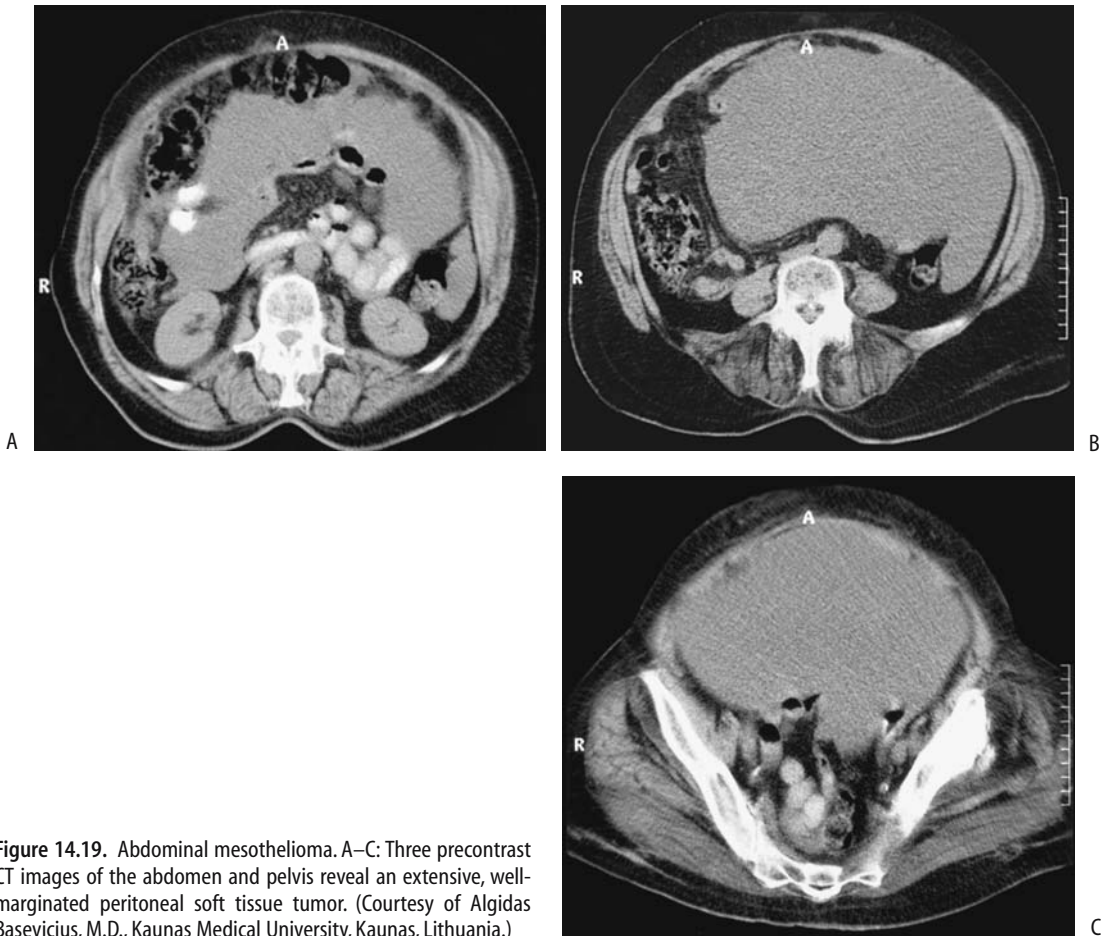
Abdominal mesothelioma. A–C: Three precontrast CT images of the abdomen and pelvis reveal an extensive, well-margined peritoneal soft tissue tumor. (Courtesy of Algidas Basevicius, M.D., Kaunas Medical University, Kaunas, Lithuania.)
